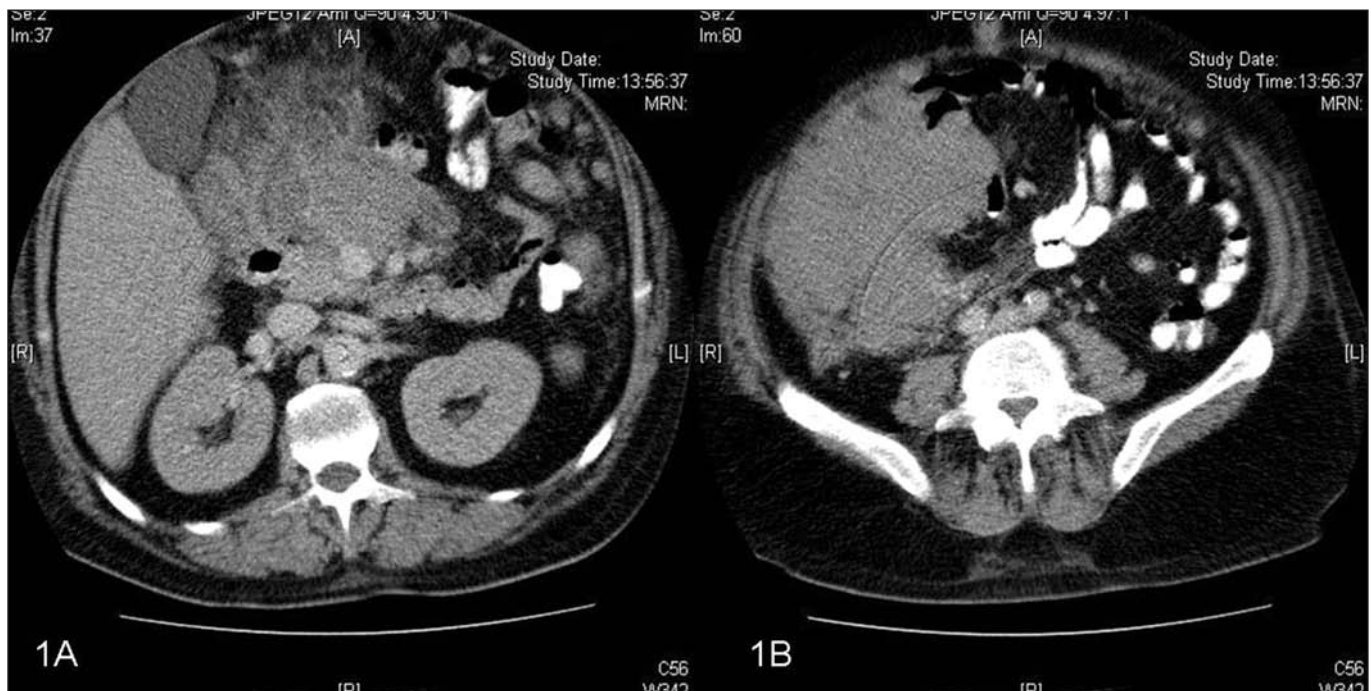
Abdominopelvic CT scan: A. Retroperitoneal mass measuring 13 x 10 cm, with no clear plane of separation between the head and the body of the pancreas. B. In the right flank a lesion that may correspond to a mass with fixed ileum and thickened wall, with a maximum diameter of 15 x 8.6 cm, may be seen.
